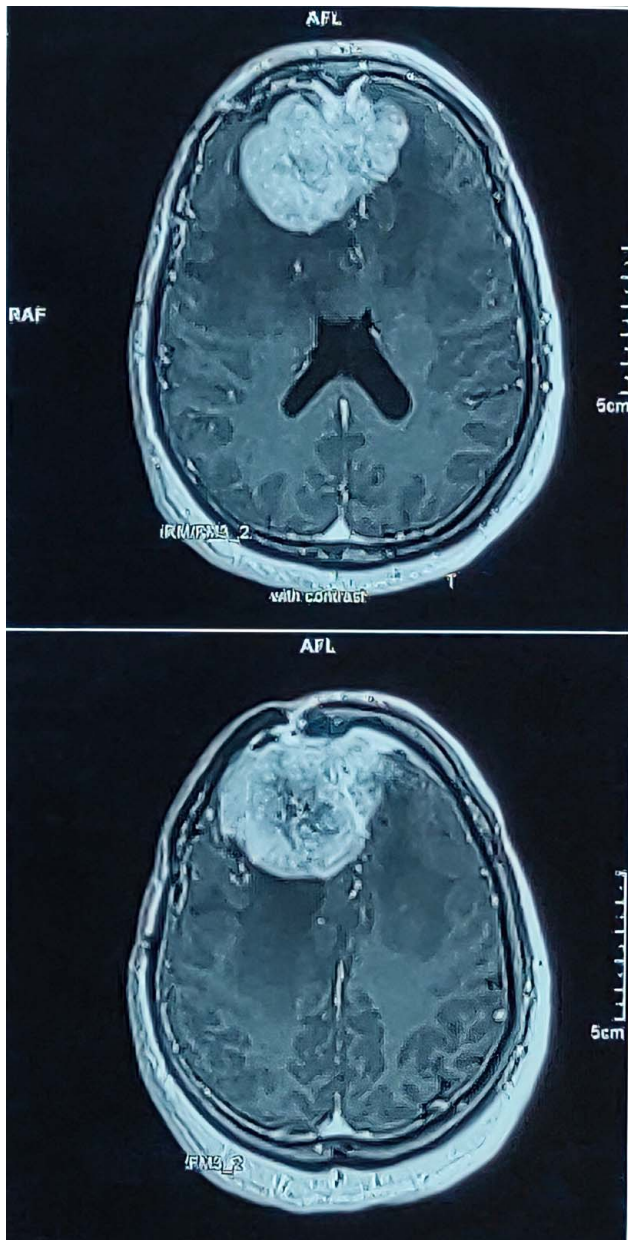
Brain MRI showing a recurrent bilateral frontal meningioma.
